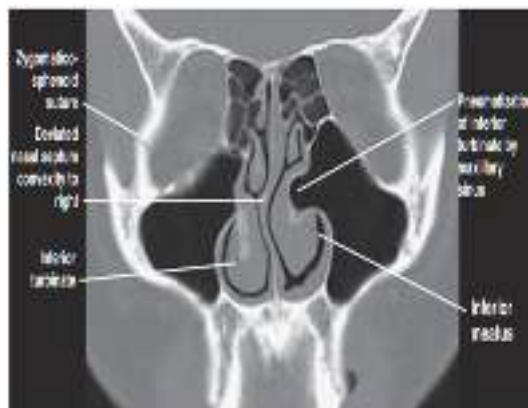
CT-Scan PNS Coronal view - Nasal septal deviation towards the right side.³⁵
